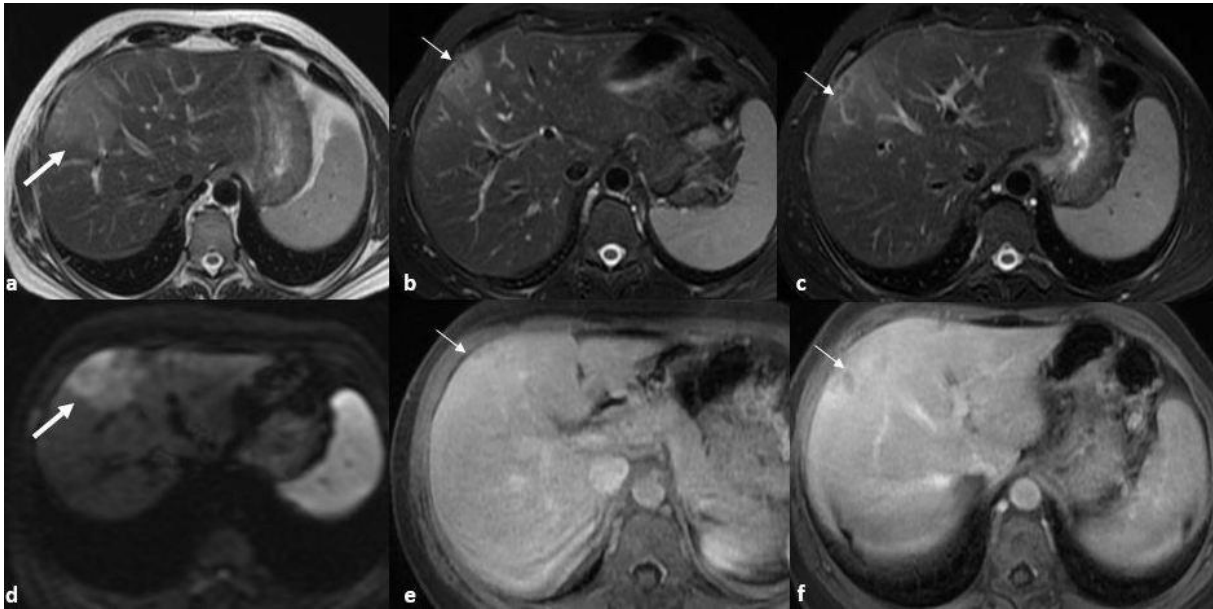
a) Axial T2 FSE image shows a peripherally located hyperintense lesion, favouring a mass. b,c) In axial fat sat T2 FSE image, hypointense tracts were seen in the lesion beneath the capsule extending centrally (thin arrow). d) In DWI, marked diffusion restriction is seen in lesions which is also observed in malignant masses of the liver. e,f) In contrast, enhanced axial fat-sat T1 weighted image, the lesion shows slightly more contrast enhancement.
